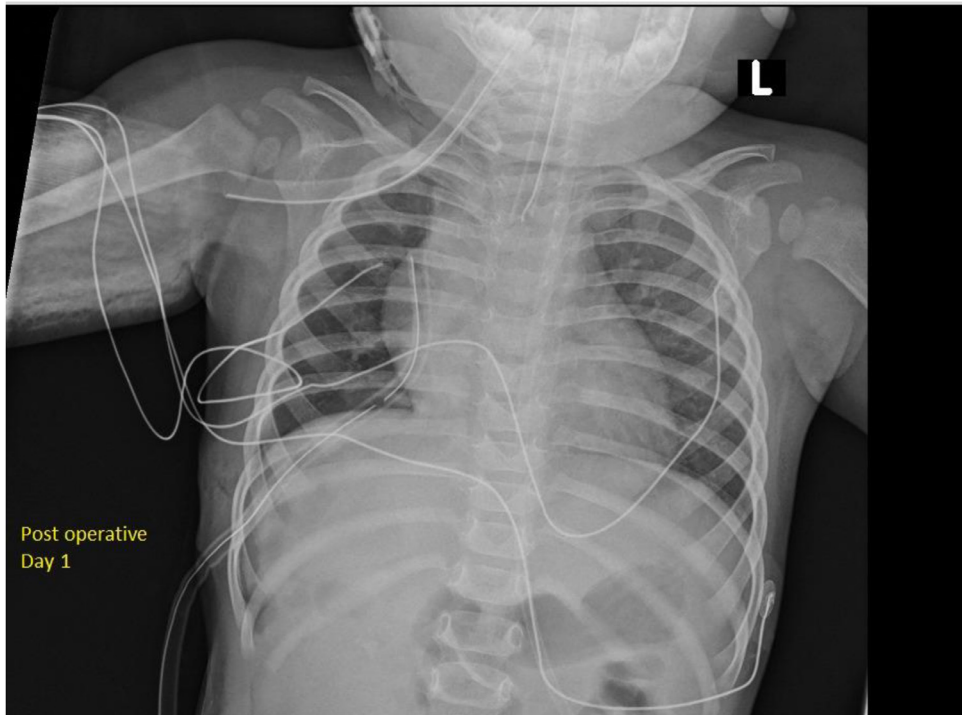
Postoperative day 1 X-ray.
